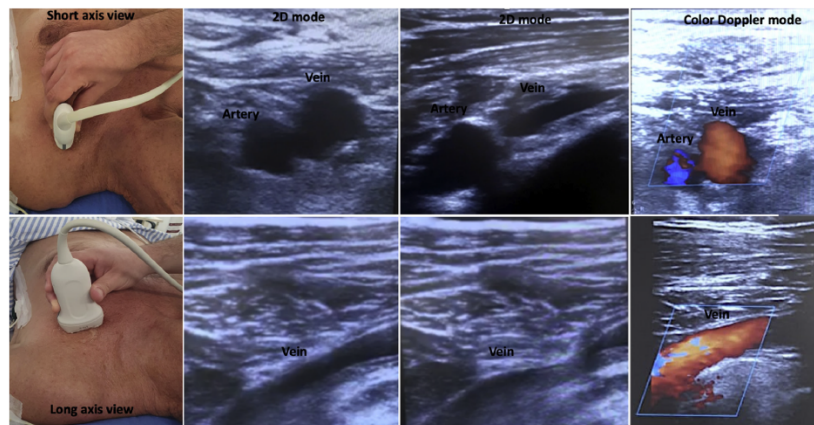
Ultrasound image of axillary vein and artery using 2-dimensional and color Doppler modes. Compressibility, lack of pulsation, and more medial and superficial position differentiate axillary artery and vein. To visualize the short axis, the ultrasound probe is held perpendicular to the vein, creating a circular image of the vessel. To visualize the long axis, the ultrasound probe is held parallel to the vein, creating a longitudinal image of the vessel.
